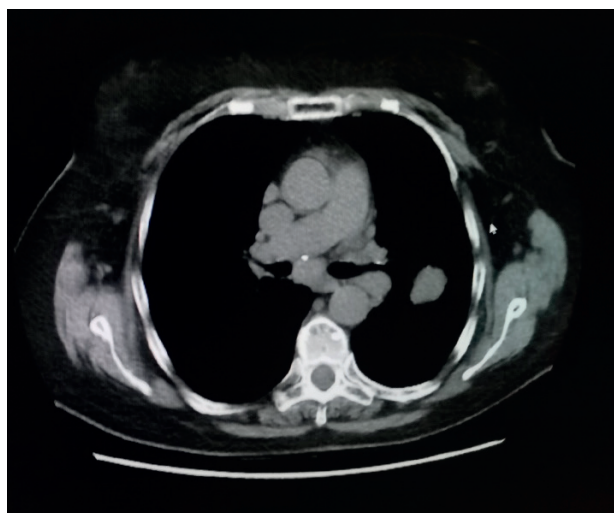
One month later CT scan showing a complete resolution of GGO and alveolar opacities with remaining nodular opacity increased in volume in the left upper lobe.
